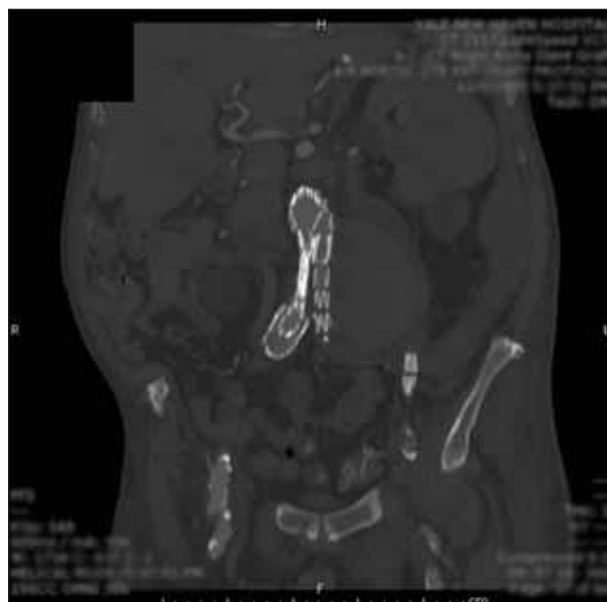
This patient, who underwent EVAR 4 years prior, presented with hemodynamic instability and a ruptured AAA. He had been lost to follow-up and had received inadequate postoperative imaging. The CT, shown here, demonstrated an AAA that had grown in size to nearly 9 cm from 5.5 cm 4 years before. There was active extravasation of contrast into the retroperitoneum.
